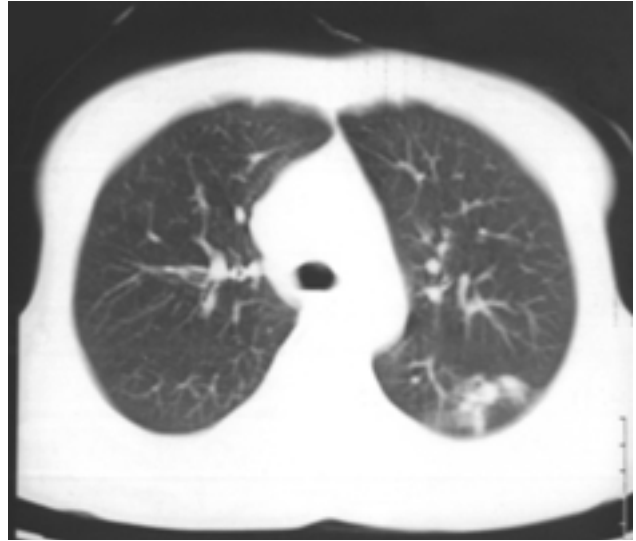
Computed tomography of the chest showing pulmonary infiltrates of the left lung
